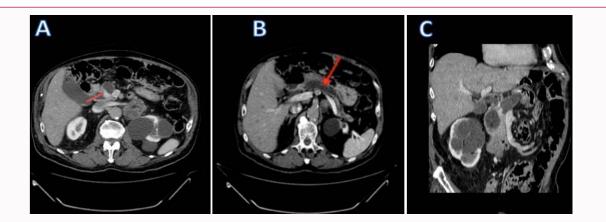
Abdominal CT scan revealed diffuse dilatation of the main pancreatic duct (20 mm) (Figure 1B); and a small hypercaptant lesion (15 mm) at the head of the pancreas (Figure 1A and C).
